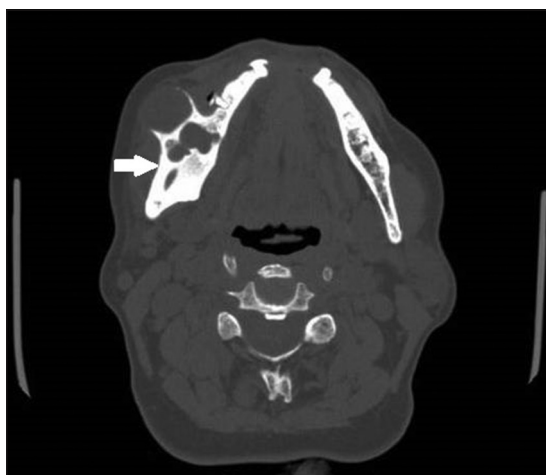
Computed tomography axial view showing multiple locules on the right side of the mandible with expansion and thinning of both buccal and lingual cortical plates
